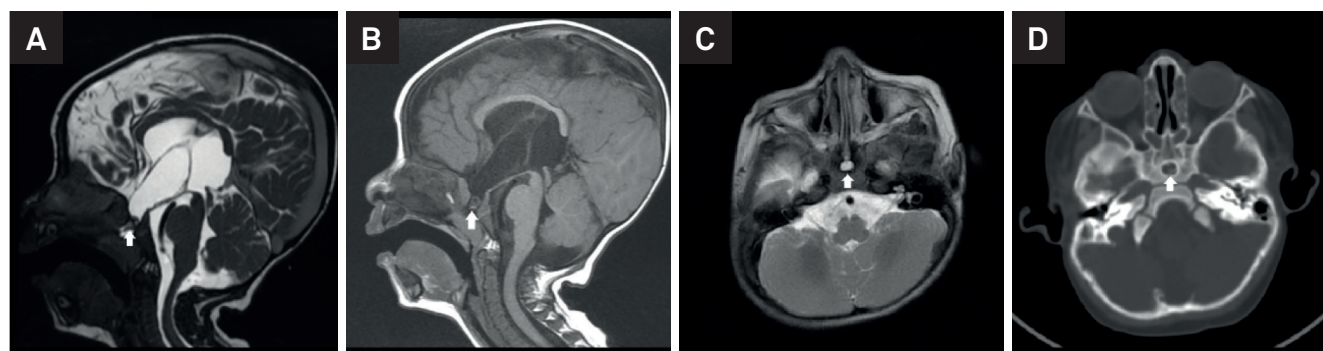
Magnetic resonance, constructive interference in steady state 3D sequence, sagittal plane; B: Magnetic resonance, T1, sagittal plane; C: Magnetic resonance, T2, axial plane; D: Computed tomography, bone window, axial plane. The persistence of the craniopharyngeal canal (arrows in C and D), and the pituitary remnant inside (arrows in A and B). Note that the remnant of the pituitary gland is lower than usual in the nasopharyngeal roof.
